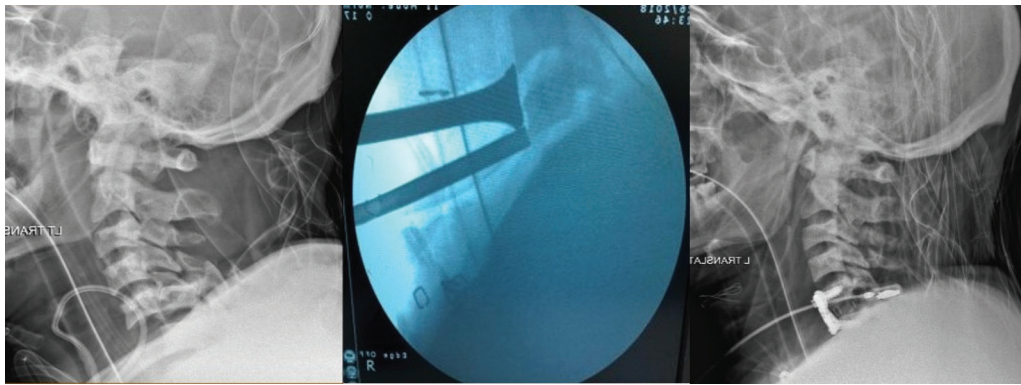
Preoperative, intraoperative, and postoperative X-ray cervical spine showing spondyloptosis (A), intraoperative manipulation being done (B), and postoperative X-ray showing complete reduction and fixation using polyetheretherketone (PEEK) cage and anterior cervical plate (C).
